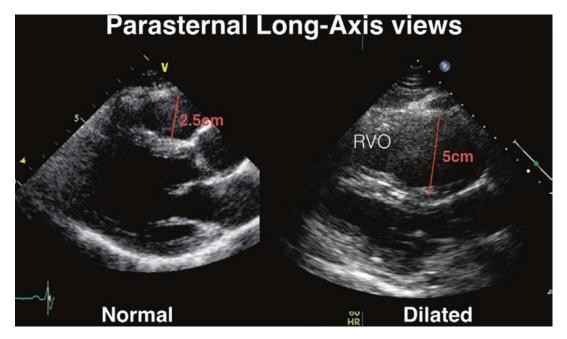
Parasternal long-axis projection from a normal individual (left) demonstrating the normal 1/3 to 2/3 relationship between the right and left ventricles respectively. In this instance the RV outflow track measures 2.5 cm. On
